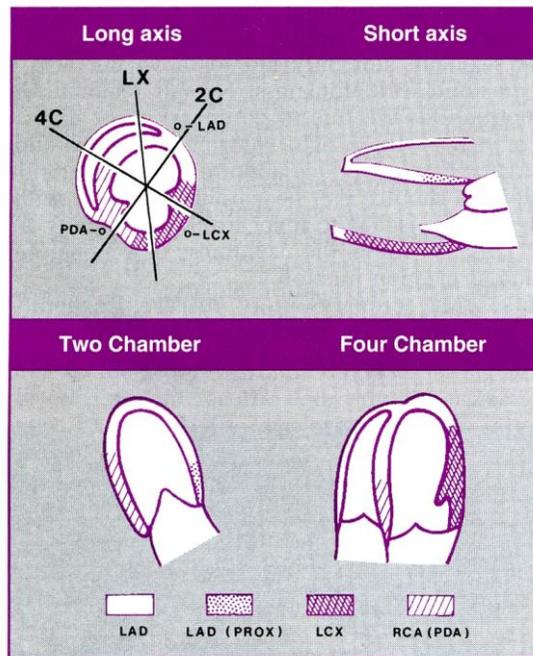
Relationship of 2-D echocardiographic views and coronary artery perfusion. 4C = four-chamber; LX = long-axis; 2C = two-chamber; LAD = left anterior descending; LCX = left circumflex artery; RCA = right coronary artery; PDA = posterior descending artery.
